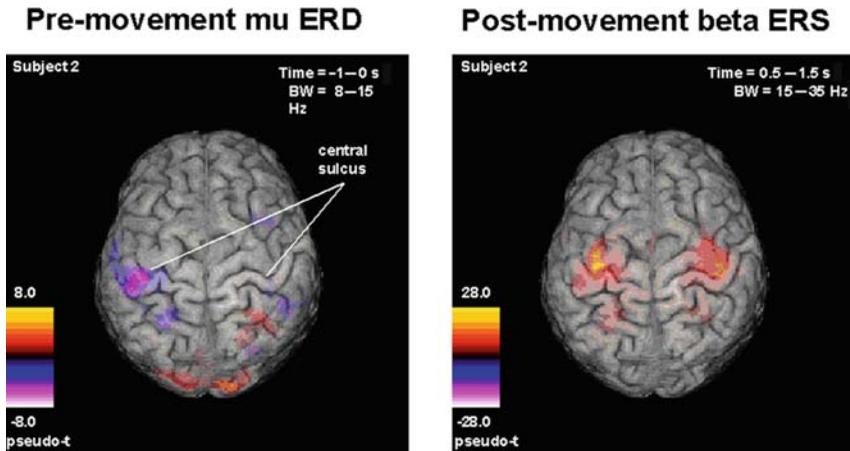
Localization of induced cortical oscillations during a voluntary right finger movement in a single subject using the SAM beamformer source reconstruction algorithm. Differential source power (pseudo-t) decreases (blue) and increases (red) are superimposed on the subject’s MRI. Left: Decreased power in the μ (8–15 Hz) frequency band during the pre-movement period is seen in the contralateral post-central gyrus and parietal areas (left). Right: Increases in the β (15–30 Hz) band begin approximately 0.5 s after movement onset and are localized to bilaterally to the primary motor cortex
